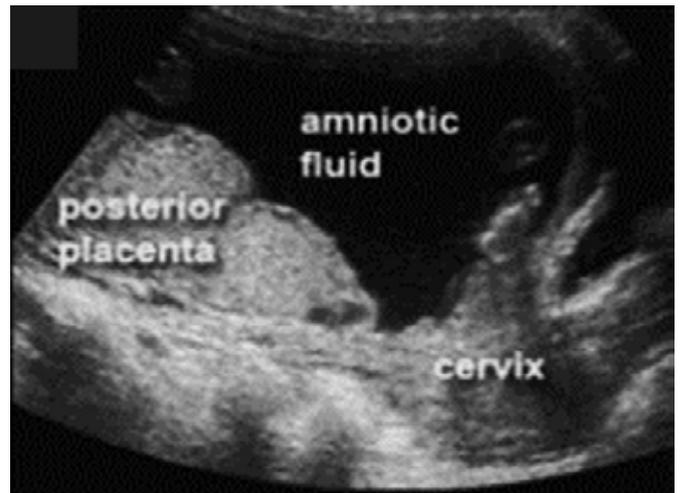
Ultrasound image of the placental location and its relationship to the internal cervical orifice (ICO)².
